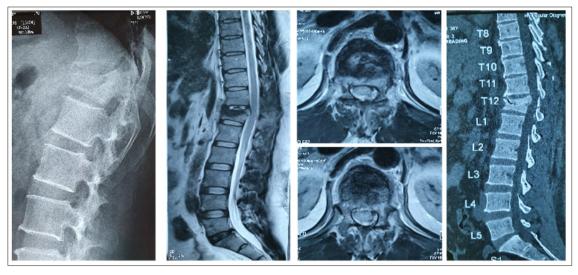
X-ray, MRI, CT Scan shows Brust fracture of D12 vertebra
